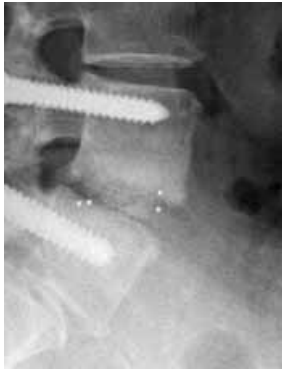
CT after 6 months reveals signs of pseudoarthrosis.
